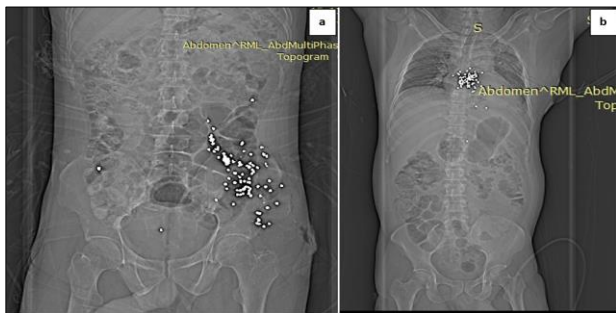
a) and b) Abdominal and thoracoabdominal bullet injury in two different patients: plain radiograph localises number and position of projectiles.
